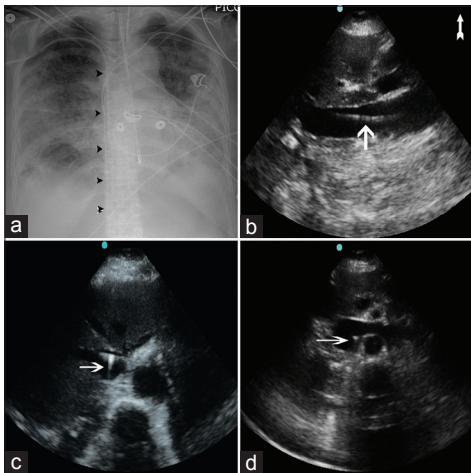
(a) Chest X-ray showing a guide wire lodged partly in the heart (arrowhead); (b) longitudinal view of inferior vena cava (IVC) with guide wire (arrow); (c) transverse section of IVC at the confluence of hepatic veins, with guidewire (arrow); (d) transverse section of IVC at the level of renal veins showing guide wire (arrow)
